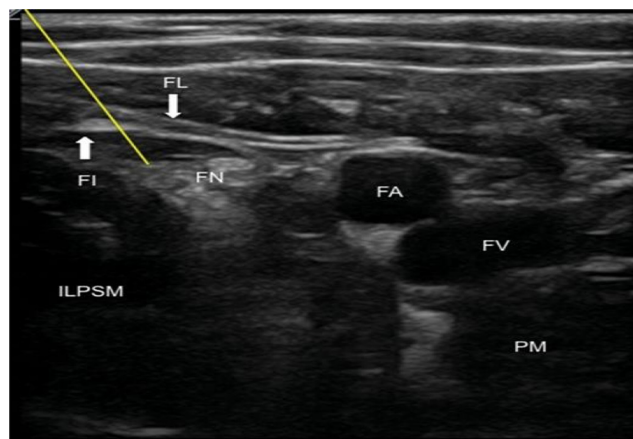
Ultrasound image of the femoral nerve (yellow line points to the femoral nerve).
